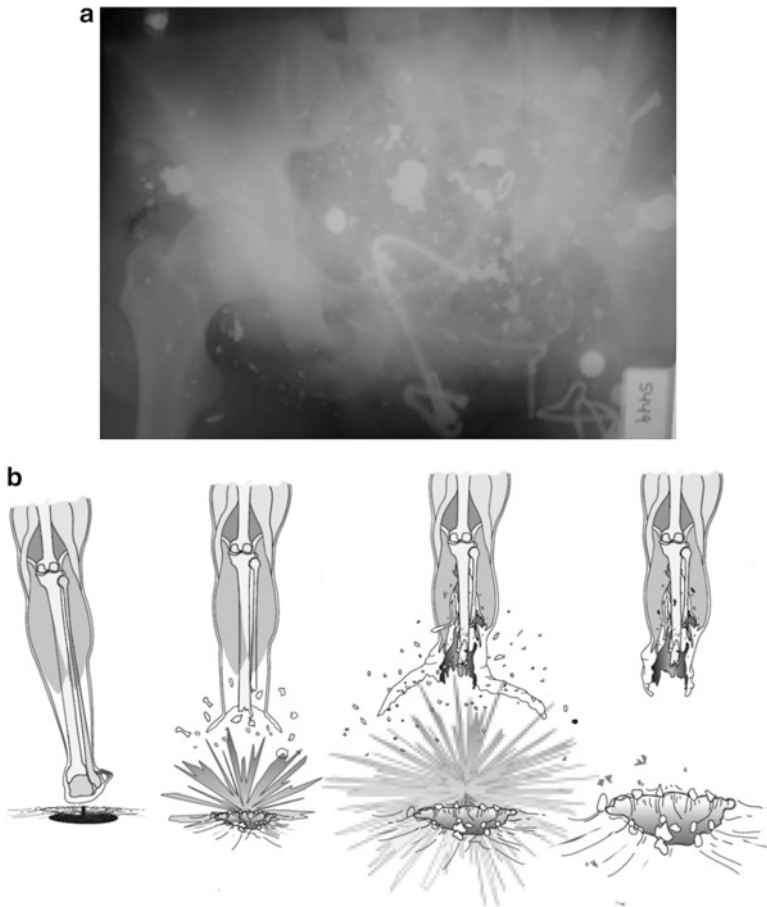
(a) Preoperative x-ray demonstrating the amount and extent of contamination forced into the soft tissues by a typical blast mechanism. (b) “Umbrella effect” of blast mechanism commonly found in military personnel on dismounted patrol that encounter the direct effects of a mine (Reprinted from *Emergency War Surgery*, 3rd Revision, 2004. Compiled by Walter Reed Army Medical Center Borden Institute, US Department of Defense, US Army. The fourth edition is available here: <https://bookstore.gpo.gov/products/sku/008-300-00050-0-0>)
